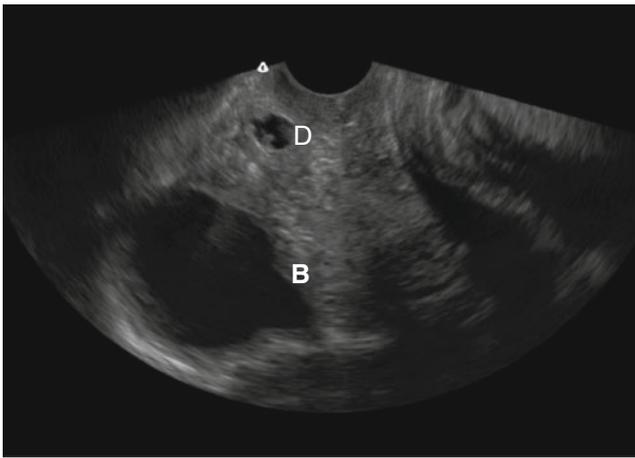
Two-dimensional ultrasound sagittal view of a urethral diverticulum (*D*). The bladder (*B*) is shown cephalad to the diverticulum
